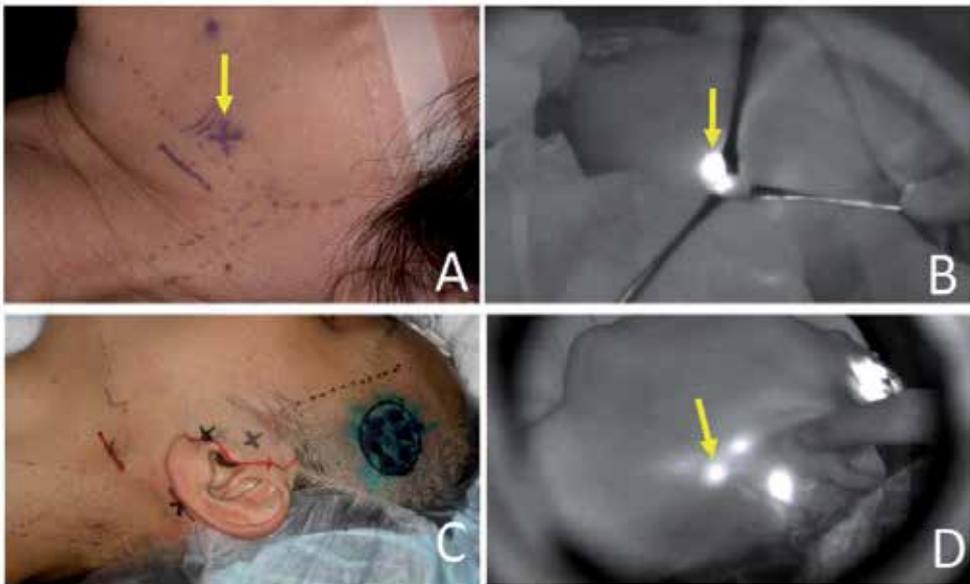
SLNB using ICG. (A) SLNB for melanoma of the nose. The X mark on the left mandible indicates accumulation of radioisotope (arrow). (B) A fluorescent submandibular SLN is visible through the incision using the near-infrared camera (arrow). (C) SLNB for melanoma of the left temporal region. The X marks indicate accumulation of radioisotope. (D) An additional fluorescent SLN (arrow), which was not detected by lymphoscintigraphy, is observed through the overlying skin.
